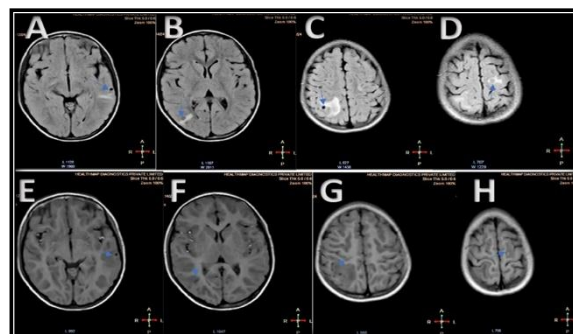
(case 6) Multiple NCC (blue arrow) seen in granular-nodular stage on FLAIR (A, B, C, D) and T1 (E, F, G, H) images with some perilesional oedema.
